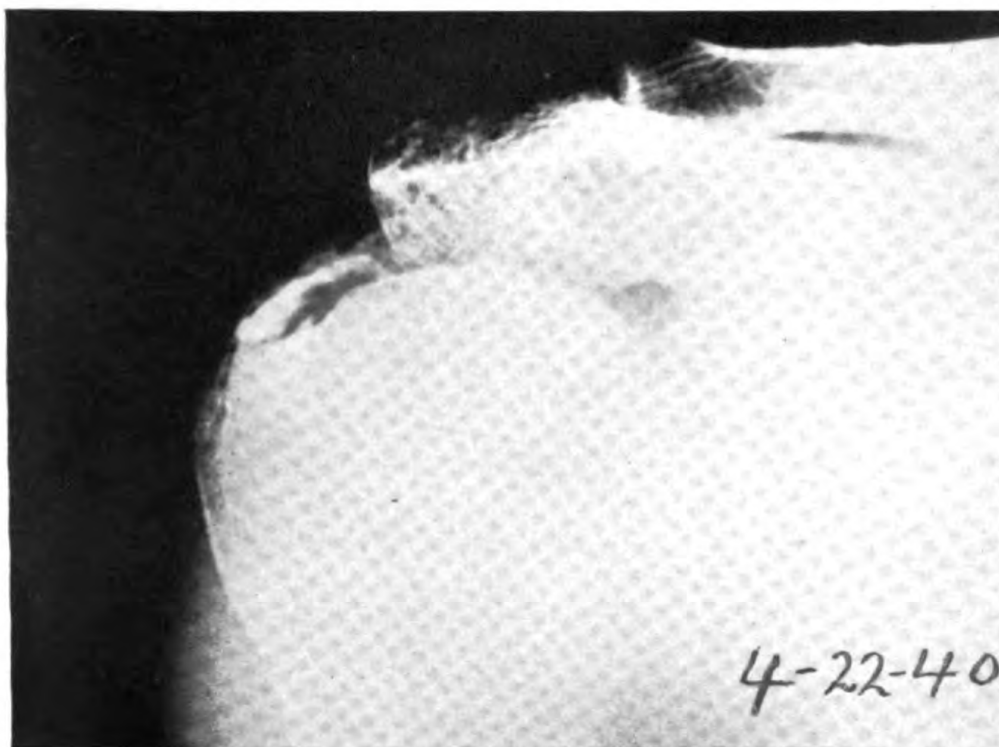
CASE 22.—ONE MONTH AFTER A SECOND COURSE OF 300 ROENTGEN UNITS.
